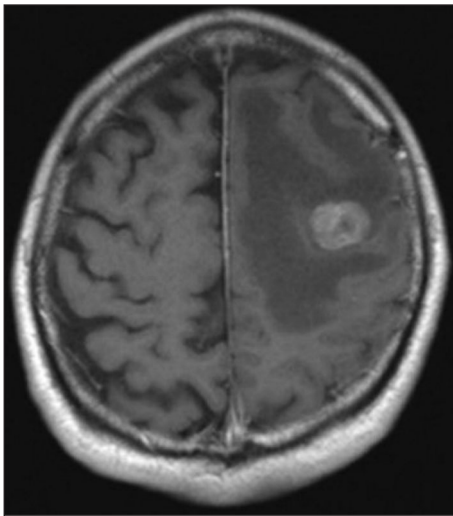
Contrast enhanced CT of the brain at axial cut showing a space-occupying lesion measuring 1.6x2.3x1.6 cm over the left precentral gyrus with perilesional edema.
